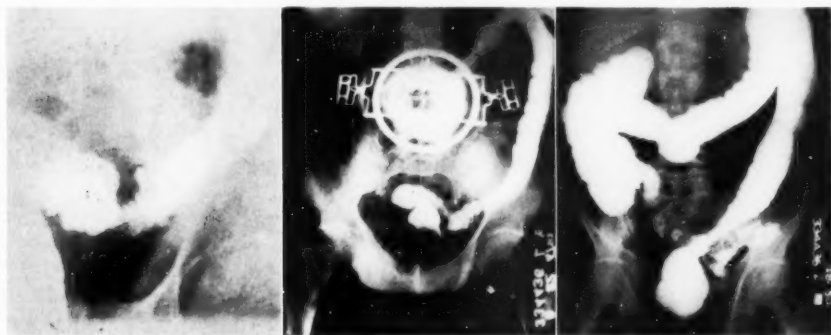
(a) X-ray visualization of an obstructing lesion for which a colostomy was done. (b) After resection one month later because of persistent inflammation. (c) Site of anastomosis after resection and closure of colostomy.
